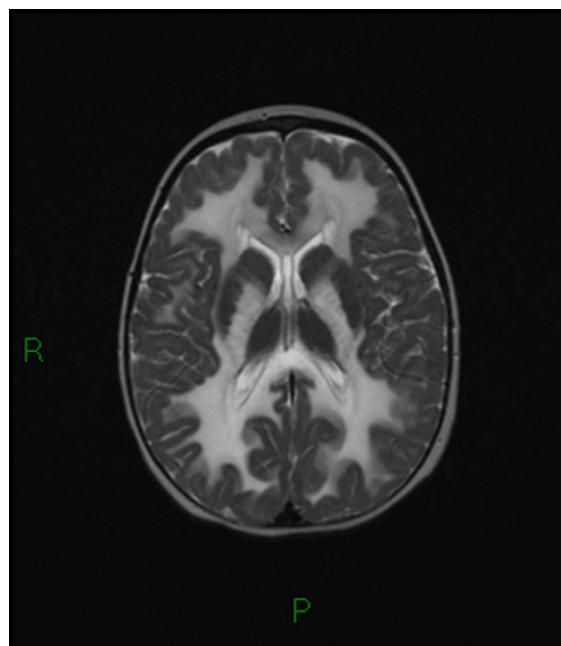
T2-weighted image showing extensive white matter signal alteration and involvement of both nuclei pallidi.
